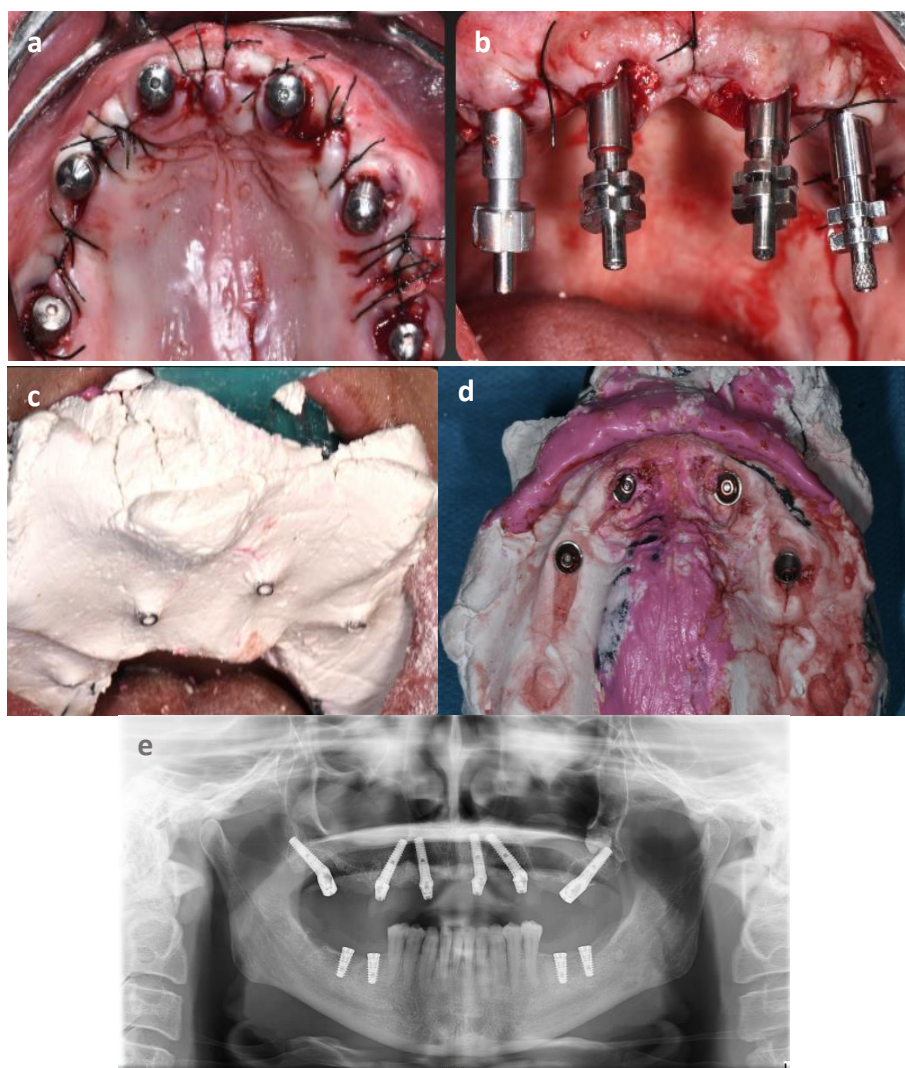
Implants and healing cups are placed, and sutures are positioned (a). A mixed plaster impression is taken with transfers positioned on the four anterior implants (b, c, and d) using a customized impression tray derived from the same aesthetic guide template and mucosal supported in the same palatine wrinkles reference area. The radiological Orthopantomography is scanned after the delivery of the milled Polymethyl Methacrylate (PMMA) provisional restoration screwed on 4 Low Profiles: let's note the radiolucent aspect depending on the absence of the armor (e).*
